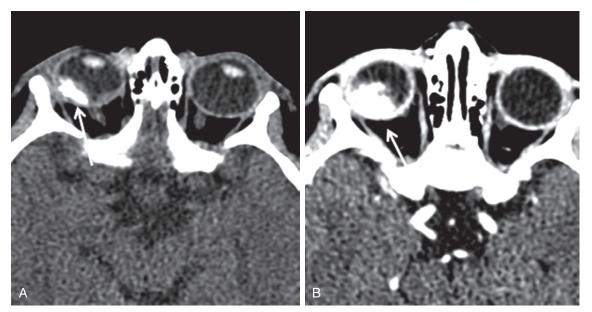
Patient with leukocoria/white eye reflex: Retinoblastoma. A, Unenhanced axial CT of the orbits demonstrates a calcified mass in the posterior aspect of the right globe (arrow). B, Contrast-enhanced CT of the orbits demonstrates an enhancing soft tissue component to the mass.
